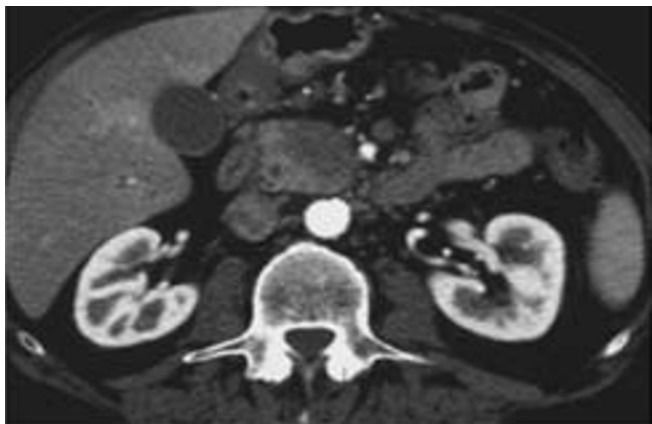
CT findings of a patient suffering from the focal form of autoimmune pancreatitis
